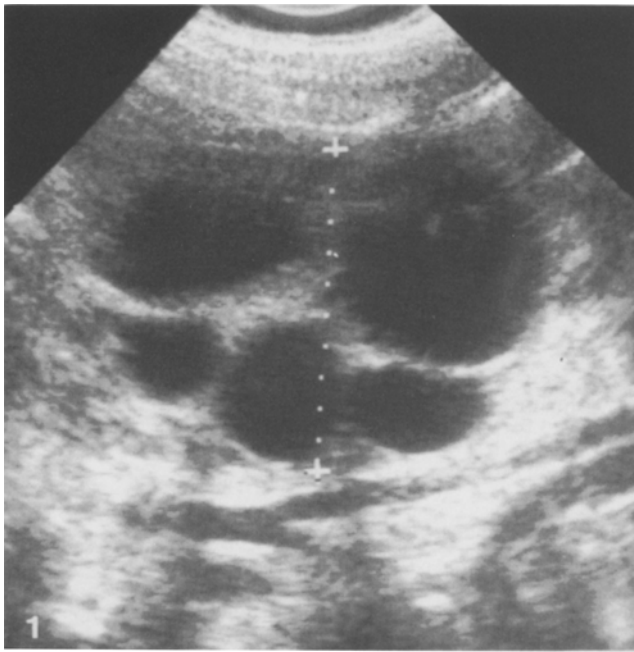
A coronal ultrasound of the left upper quadrant in this 4-day-old girl reveals a characteristic appearance of multicystic dysplastic kidney
